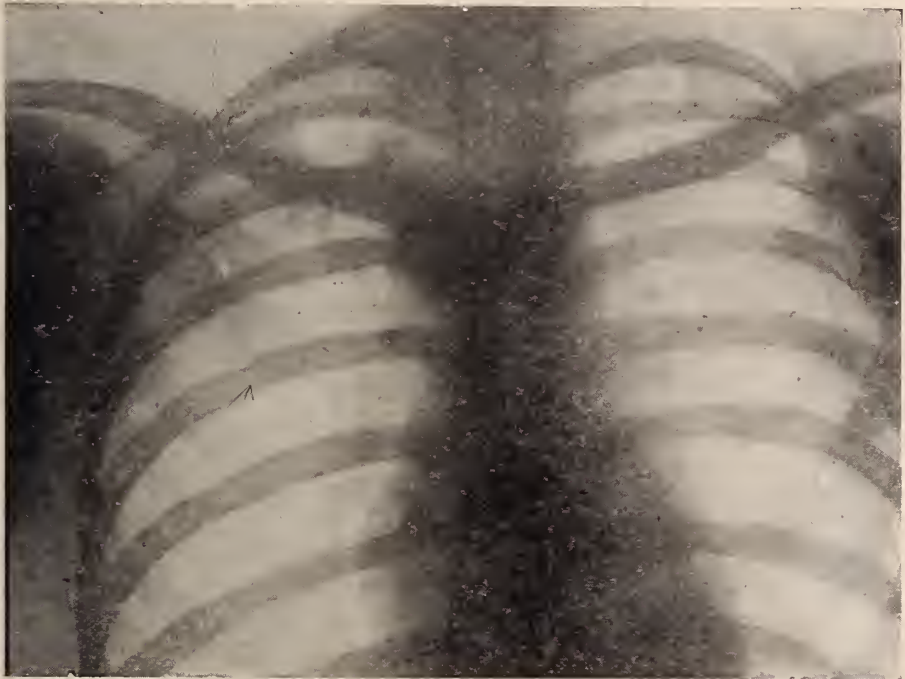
In this case the invasion was insidious without appreciable inroads on the general health; there were tubercle bacilli in the sputum, but it was difficult to convince either patient or physician of the gravity of the condition. The X-ray shows that the activity extends more rapidly than the fibrosis, so that the patient is not holding his own regardless of what the physical findings or general health may have to say.
